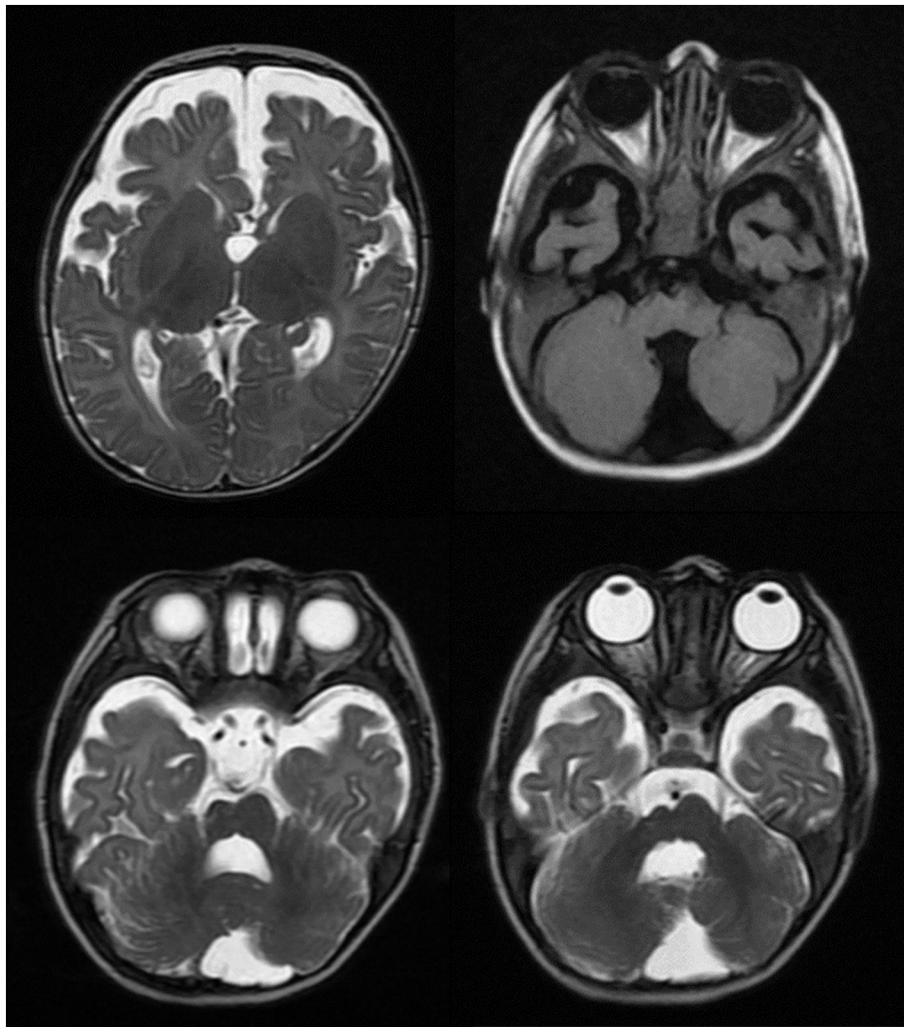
Axial T2W brain MRI of proband. Images show prominence of sulci, and brain atrophy in bilateral frontal temporal regions and agenesis of the corpus callosum.
